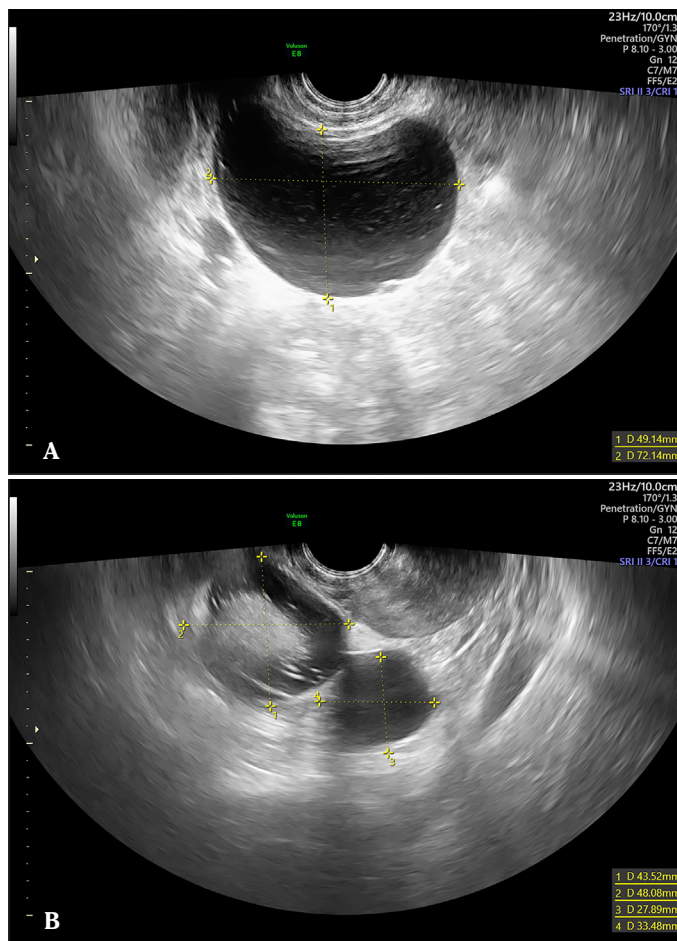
Transvaginal ultrasound imaging showing A) a unilocular cyst with low level echogenicity in the right ovary. B) two ovarian cysts: one is a unilocular cyst and the other exhibits hyperechoic lines and dots in the left ovary
